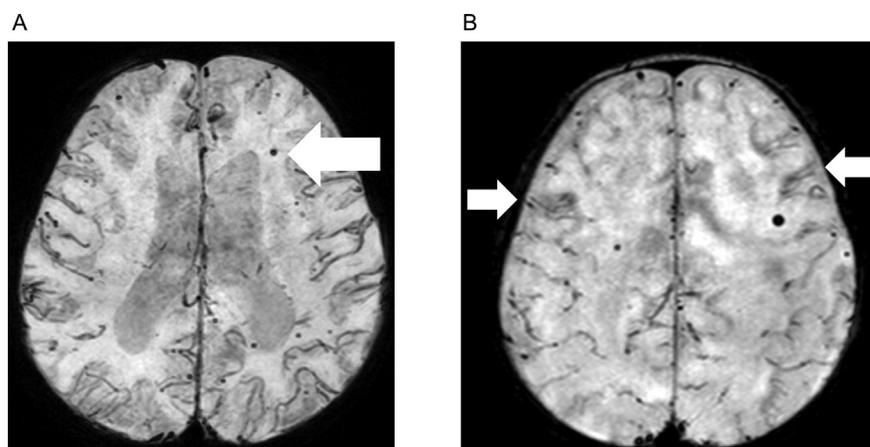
A: The susceptibility-weighted (SWI) sequence of the cranial MRI of a male Down syndrome patient (age: 1 year, 8 months) shows multiple cortical and subcortical lobar cerebral microbleeds, the white arrow points to an exemplary microbleed in the left frontal lobe. B: Biparietal cortical superficial siderosis (as indicated by white arrows) and multiple microbleeds in a male Down syndrome patient (age: 1 year, 8 months), susceptibility-weighted (SWI) sequence of the cranial MRI.
